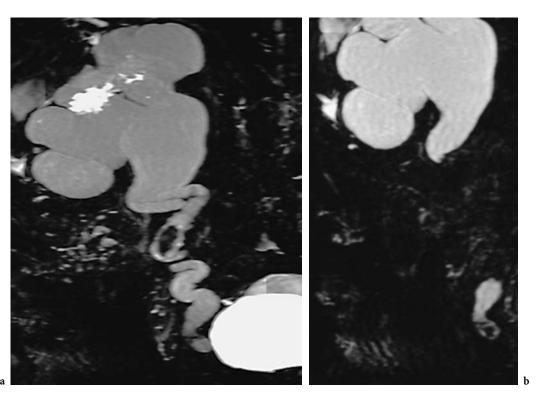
Coronal oblique thin MIP 3D heavily T2-weighted MR urogram (a) shows marked pyelocaliectasis and ureterectasis with multiple ureteral kinking of the right urinary tract; a stone in the proximal ureter is clearly identified. Oblique thin MIP 3D heavily T2-weighted image (b) reveals another small stone in the distal right ureter
